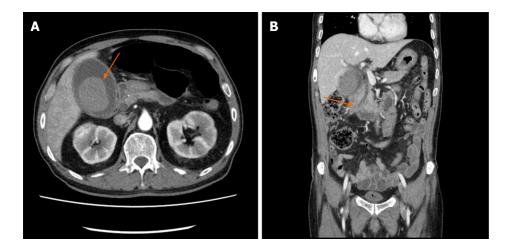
A 55 mm × 40 mm hematoma was seen in the initial computed tomographic scan. A: The Hounsfield unit values of the gallbladder stonelike lesions ranged from 60 to 67, and no gallbladder wall defect lesion was found (arrow); B: Dilatations of the intrahepatic and common bile ducts are seen (arrow), and there was a suspicion of distal common bile duct obstruction.
